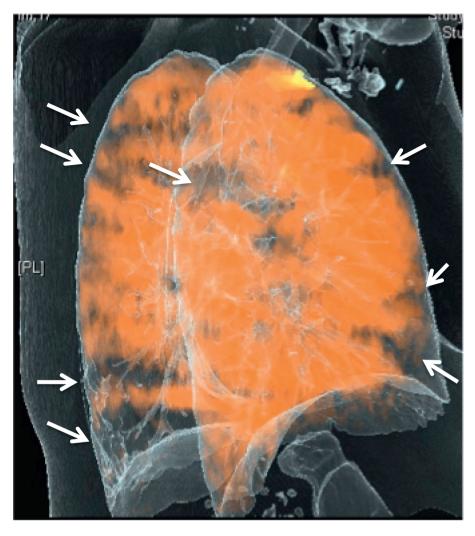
Dual-energy computed tomography derived iodine map depicting multiple perfusion defects.
